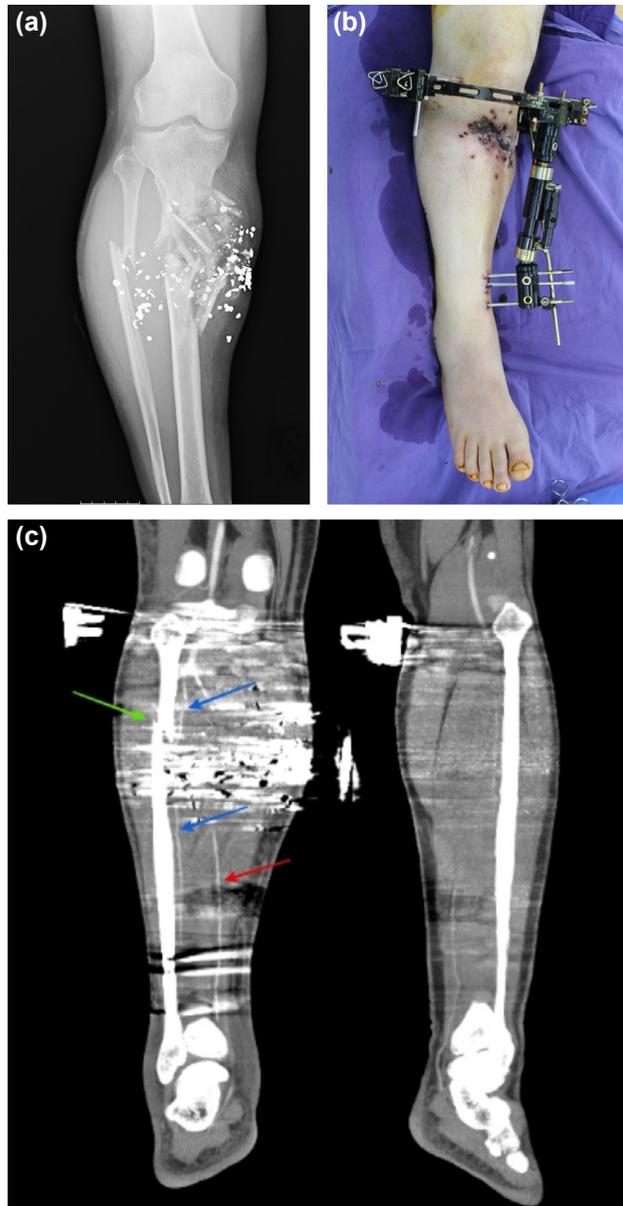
Anteroposterior X-ray view of the proximal cruris before the first operation. It is seen that there is one horizontal fracture in the proximal fibula and a butterfly fracture in the proximal tibia as a result of a high-energy gunshot injury. (a) After the external fixator application, the appearance of the cruris is shown. There is near total necrosis of the region close to the tibial plateau due to entrance wounds caused by shotgun pellets. (b) The evaluation of the wounded lower extremity in computed tomography angiography preoperatively. The fibula fracture line (green arrow), the sight of the filling of contrast material of the posterior tibial artery (red arrow) and both proximal and distal parts of the peroneal artery (blue arrows) are seen (c).
